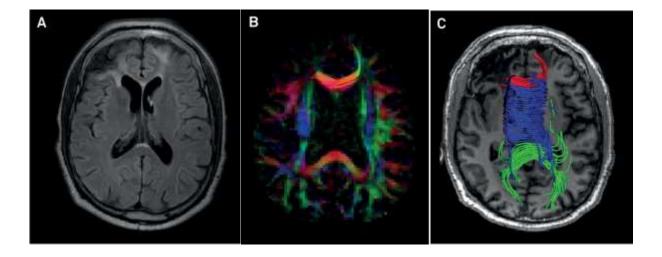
Axial FLAIR image of an adult male patient with chronic post-traumatic sequelae shows gliosis in the frontal lobes, mainly in the right side (A). FA colormap demonstrates paucity of WM fibers and reduction of brightness due to reduction of FA values in the frontal lobes, more pronounced in the right side (B). DTI-based tractography of the splenium, body
